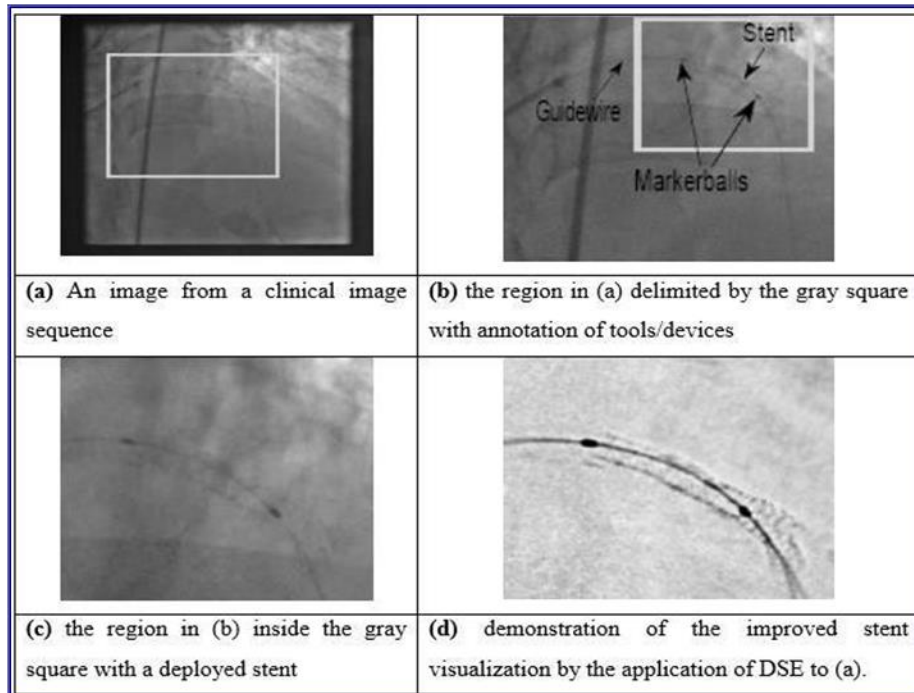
Stent visualization enhancement in X-ray image sequences [25].
